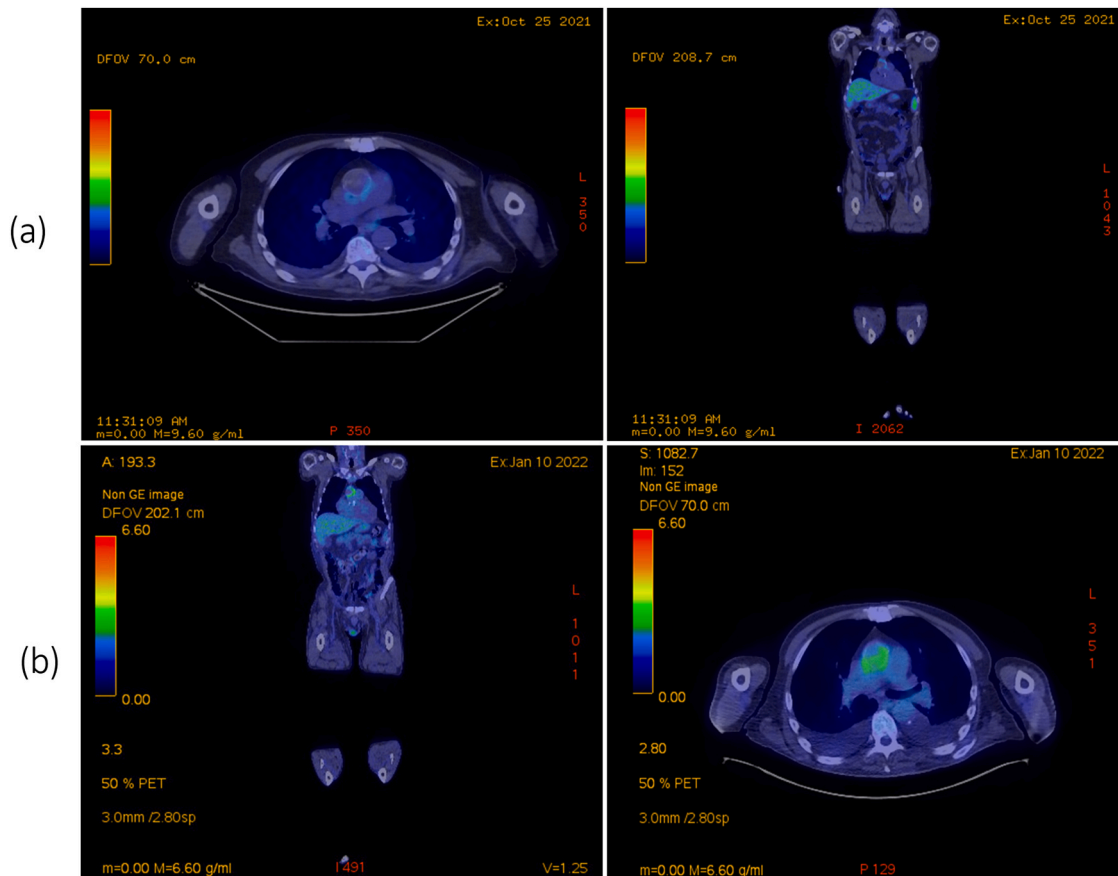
(a) [18 F]Fluorodeoxyglucose Positron Emission Tomography and CT (FDG PET-CT) obtained on initial presentation showed intraluminal linear high density at the superior margin of the ascending aorta graft with partially circumferential FDG uptake along the intraluminal density and about the aorta extending to the aortic root. (b) Repeat PET-CT on readmission showing interval progression of FDG avid mycotic infection involving the root of the aorta.
